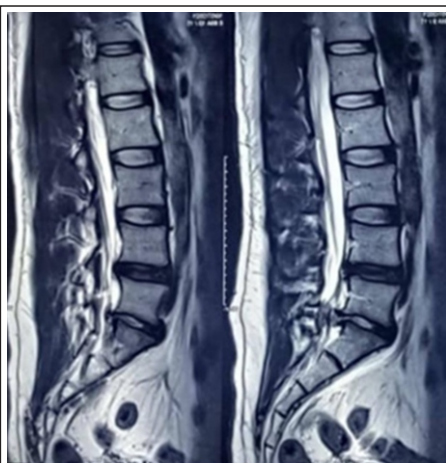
MRI LS spine of a 37-year male, with large sequestration of PVID at L5-S1. Planned for Tubular Micro-endoscopic Discectomy under spinal anesthesia.
